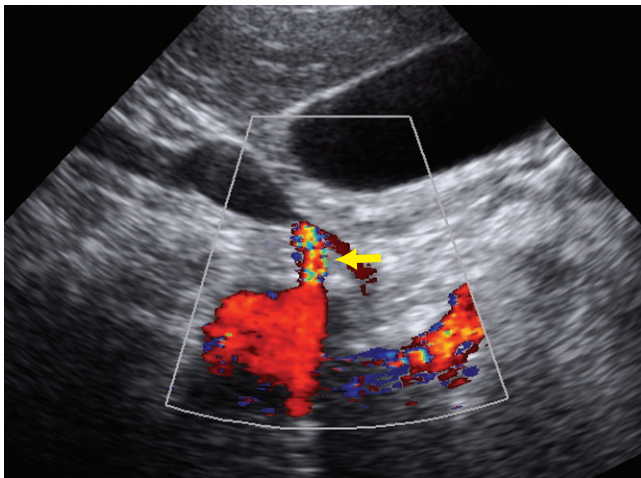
The sonographic image shows aliasing (arrow) at the origin of the right renal artery.
